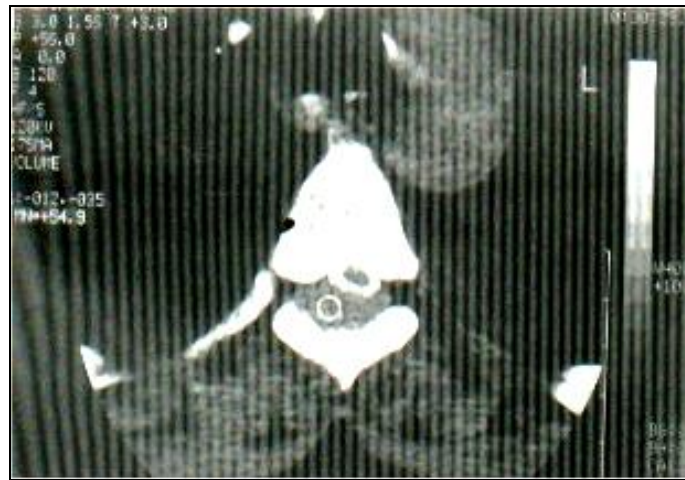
CT myelogram in axial view, at the T6 level shows a large posterior extradural tissue mass, producing compression and anterior displacement of the spinal cord (*Ben Rejab et al., 1999*).
